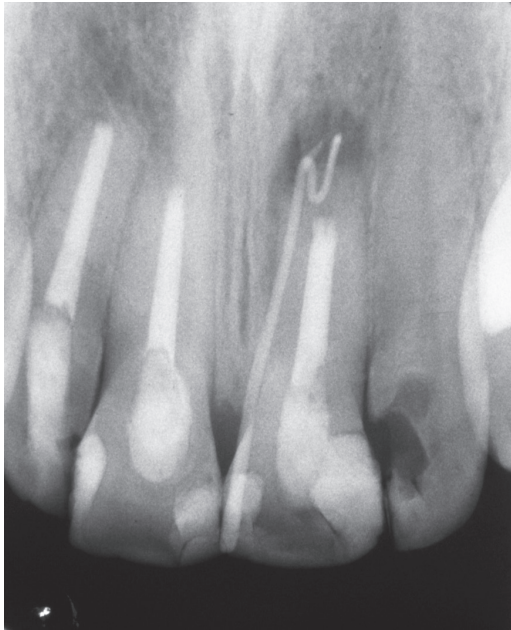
Preoperative radiograph. The root canal filling seems to be short of the apex probably due to an extensive beveling of the root tip during apex resection. No attempt at retrofilling is evident.
